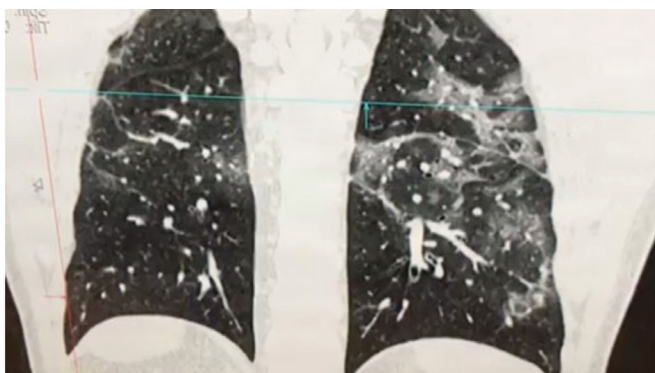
Thorax CT when symptoms appear. Bilateral lung involvement due to viral pneumonia
